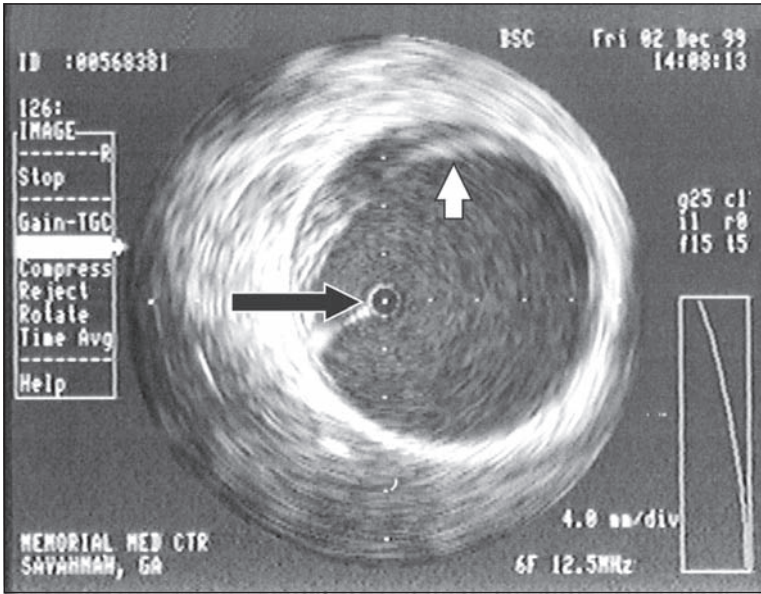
Intravascular ultrasound demonstration of a blunt aortic injury. The small arrow represents the intravascular ultrasound probe. The large arrow represents an intimal flap with intramural hemorrhage.
